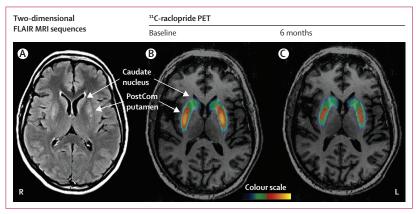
PET and MRI studies
